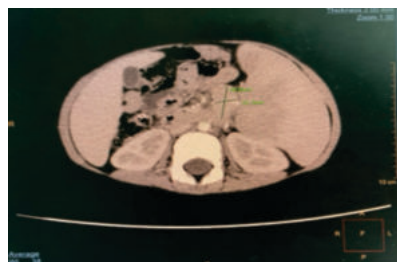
CT abdomen showing mass in splenic hilum.
